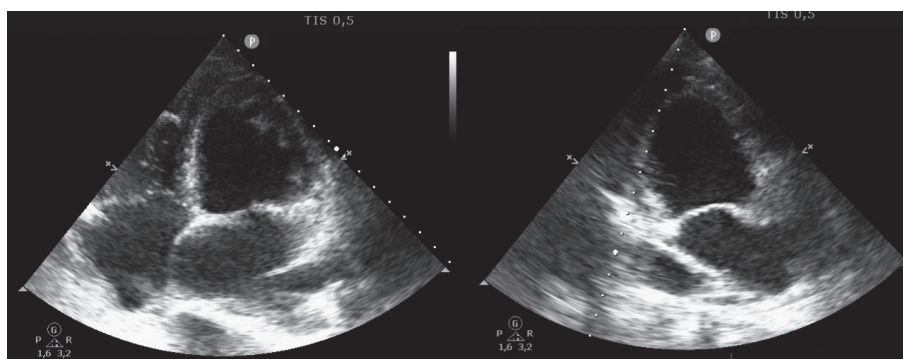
Echocardiogram four-chamber and two-chamber views during systole showing basal and mid-ventricular hypokinesia, with preserved apical contractility
